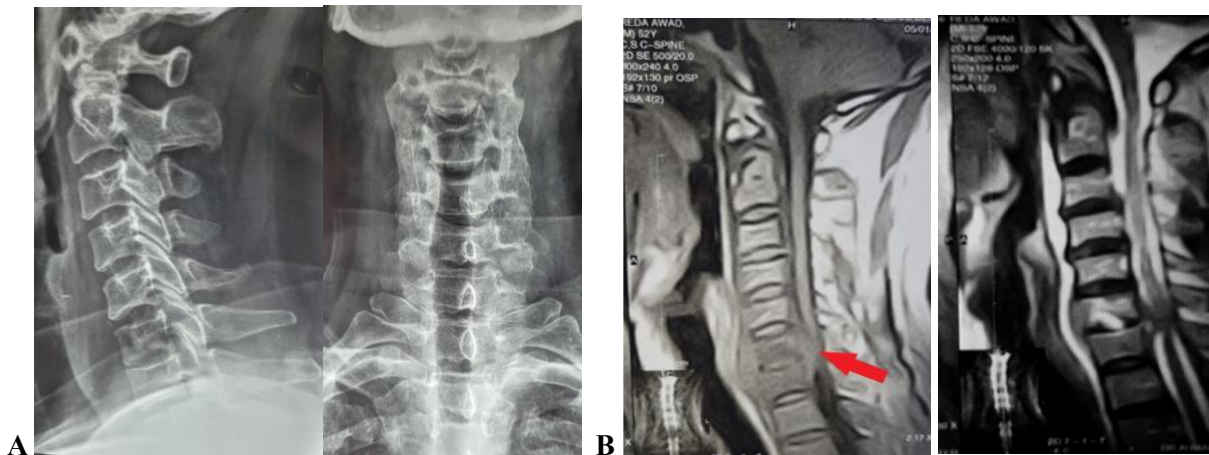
[A]: preoperative x-rays anteroposterior and lateral views, upper end plate of C5 is eroded (white arrow) , [B]: T1 and T2 MRI sequences showing C4-5 CSD with abscess formation (red arrow) severely encroaching the spinal cord,[C] : Final follow up x-rays anteroposterior and lateral views .
